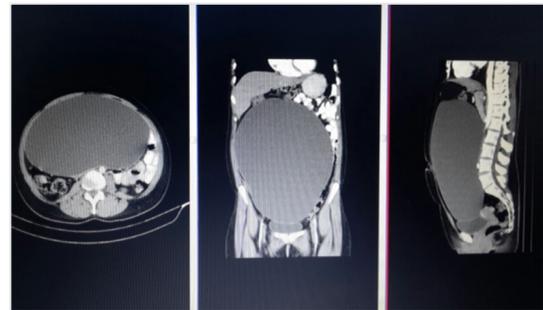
Intraabdominal placement of the cyst on computed tomography (cyst walls marked with an arrow)
